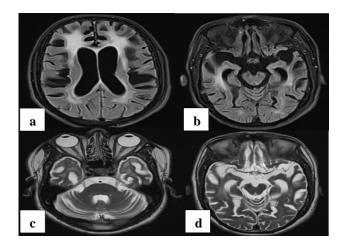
34-year PLHA male presented with altered sensorium; (a) and (b) FLAIR; (c) and (d) T2W images reveal symmetric, confluent periventricular hyperintensities involving deep and periventricular white matter along with involvement of subcortical Ufibres in bilateral frontal region and atrophic changes.
